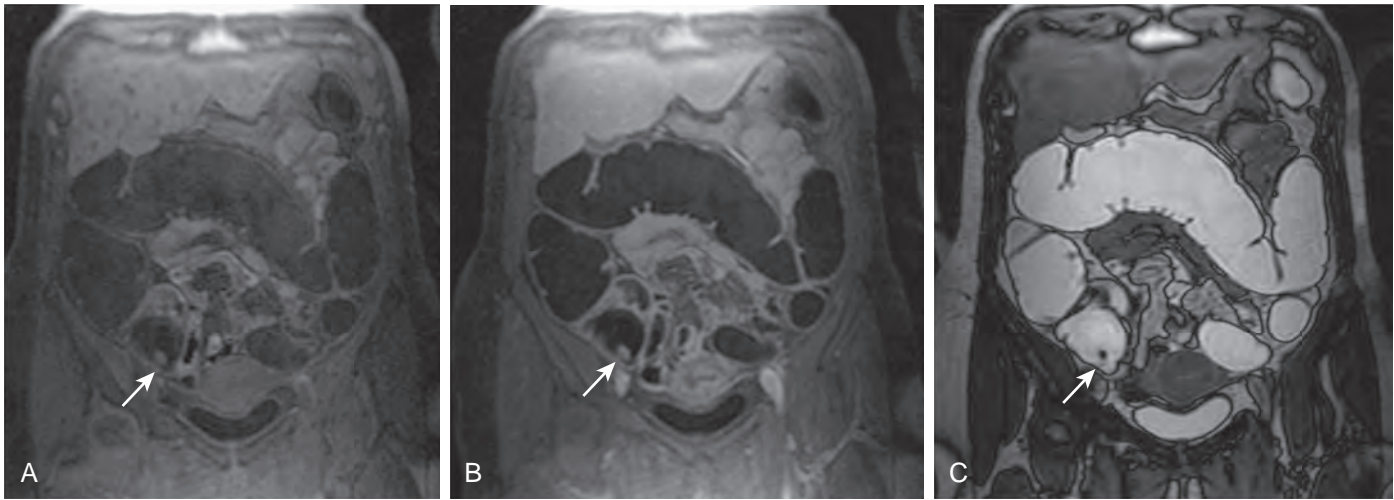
Appendectomy scar artifact. Scar tissue following appendectomy (arrow) may mimic a colonic polyp (C) because of strong contrast uptake comparing the pre- (A) and postcontrast (B) T1-weighted scans.
